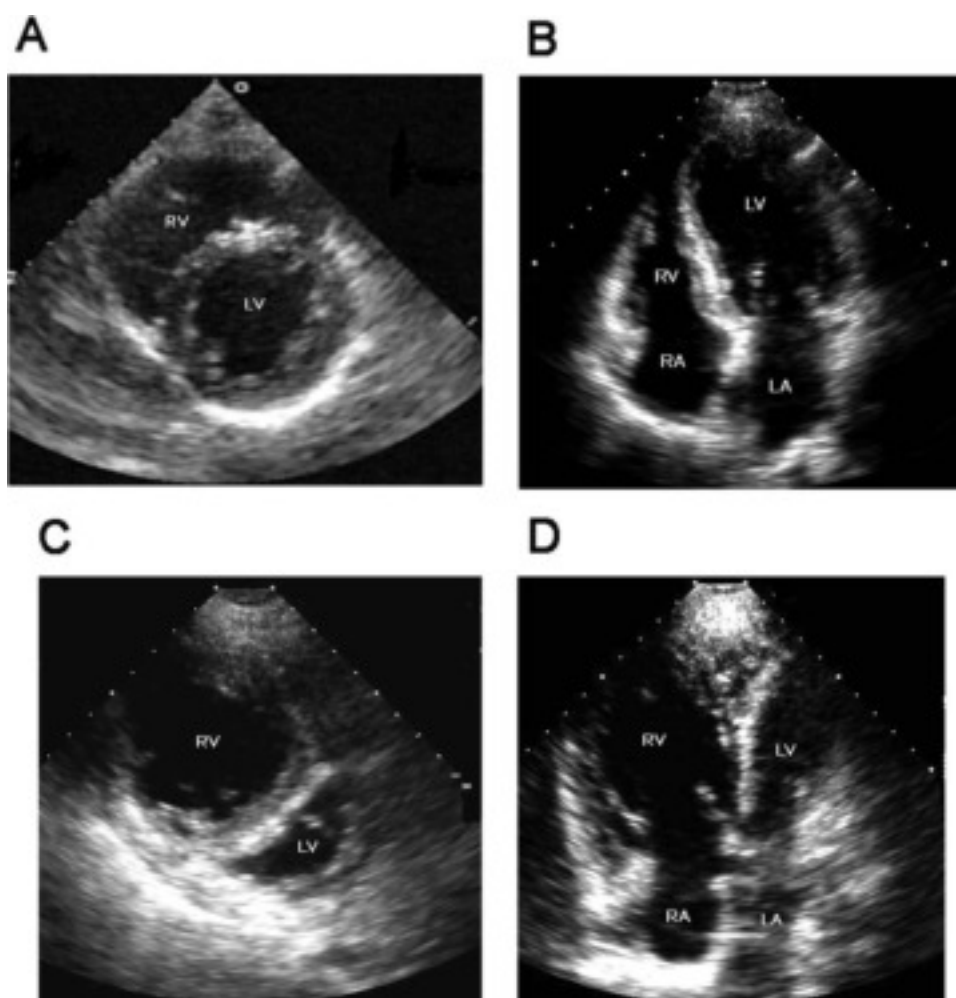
Severe RV failure and dilatation. *Top left, A:* Normal transthoracic, parasternal, short-axis view of the LV and RV at the midpapillary muscle level. *Top right, B:* Normal, transthoracic, apical, four-chamber view of the LV and RV in a normal heart depicting the relationship between the LV and RV, with the LV being normally larger than the RV, and the IVS bulging slightly toward the RV. *Bottom left, C:* Transthoracic, parasternal, short-axis view of the LV and RV in a patient with severe RV failure and dilatation. The RV cavity is seen to be much larger than the LV cavity. Because of the high volume and pressure in the RV, the IVS is bulging toward the left. This gives the LV a characteristic D-shaped appearance. *Bottom right, D:* Transthoracic, apical, four-chamber view of the same patient showing again the inverse relationship between the LV and RV sizes. The RV dilatation can take place only if associated with a proportional reduction in LV diastolic dimension (“ventricular interaction”). This reduction in LV diastolic dimension will significantly impair LV relaxation and change the pressure-volume relationship of the left heart chambers.
